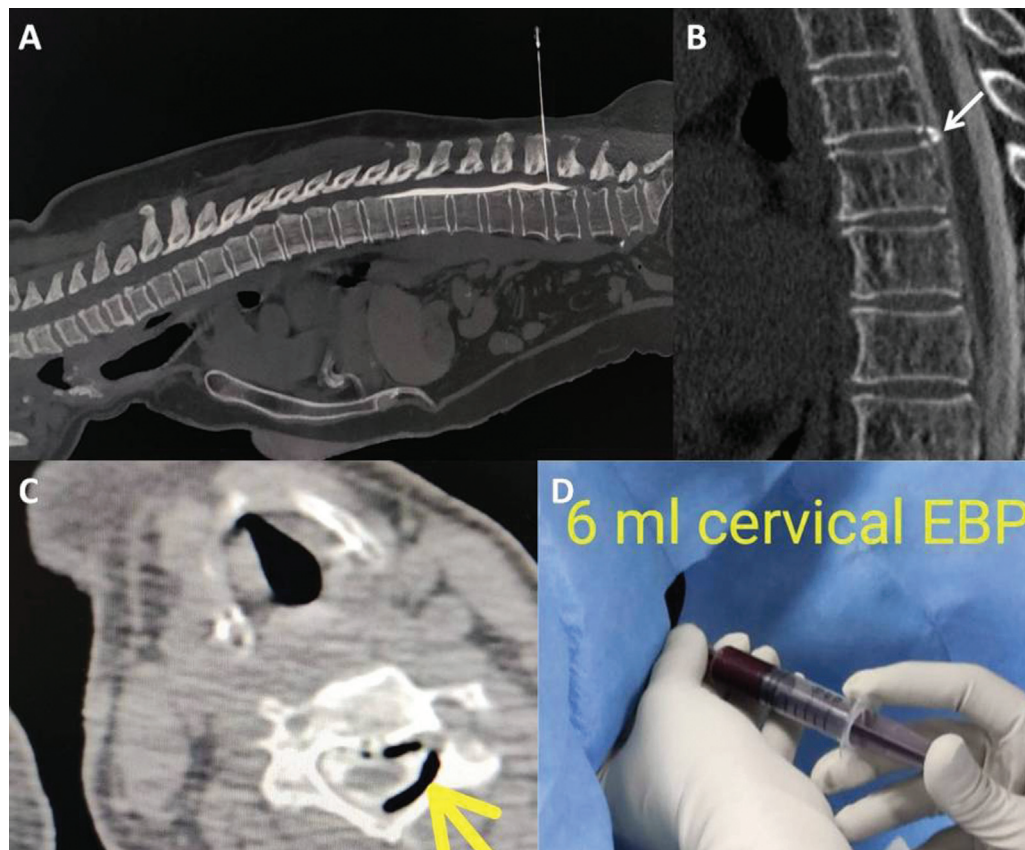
Computed tomography (CT) myelogram procedure. (A) Injecting CT contrast through lumbar puncture technique in Trendelenburg position. (B) Sagittal CT myelogram showing bony spicule along the posterior aspect of the disc (arrow). (C) Epidural air confirms the needle is in epidural space before injecting autologous blood (yellow arrow). (D) Localized epidural blood patch (EBP) in prone position.
